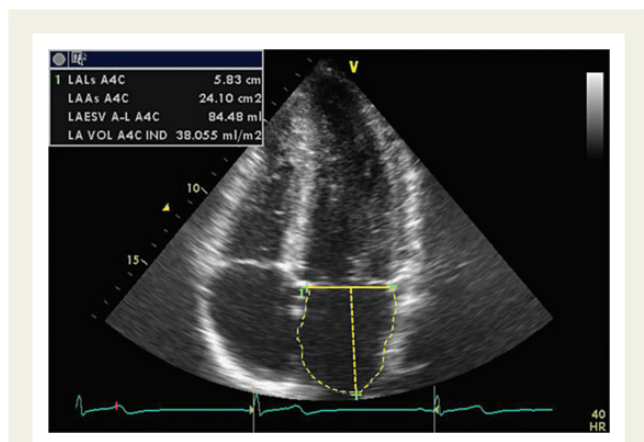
Left atrial dilation in an endurance athlete (rower). The current ASE/EAE recommendations on LV diastolic function indicates a cut-off point $\geq 34 \text{ mL/m}^2$ to define LA enlargement (see Nagueh SF et al.⁸³). Accordingly, LA volume index = 38.055 mL/m^2 of this rower is consistent with LA enlargement. However, the development of athlete-specific normalcy criteria, ideally partitioned according to gender and sport activity, could help avoid labelling such left atrial dilation as pathological. LALs 4Ac, LA longitudinal diameter in apical four-chamber view; LAAs A4c, LA area; LAESV A-L A4C, LA end-systolic volume; LA Vol IND, LA volume index.
